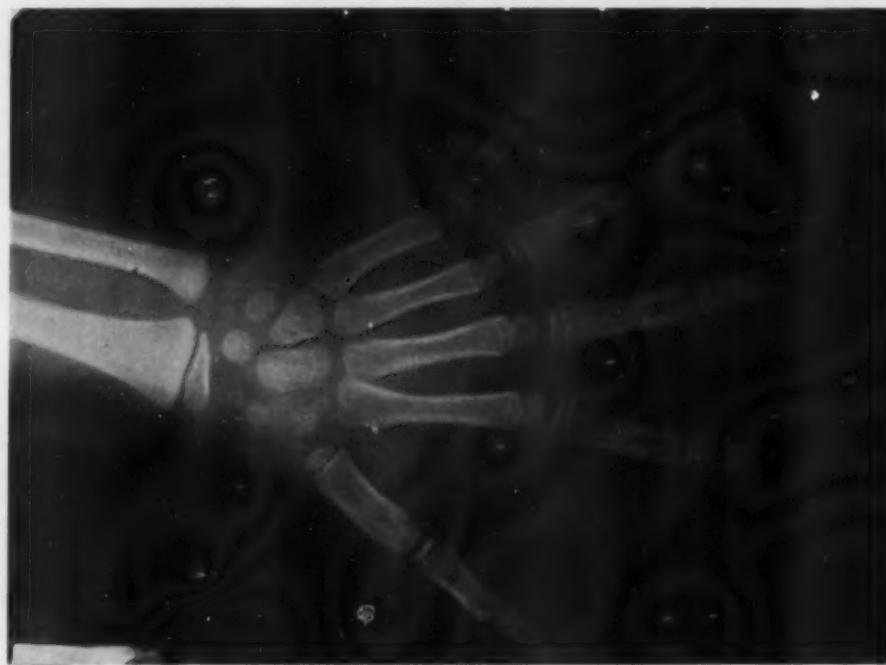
Roentgenogram of the same hand on Quix paper, No. 1. Exposure, three-fourths second (with intensifying screen).
